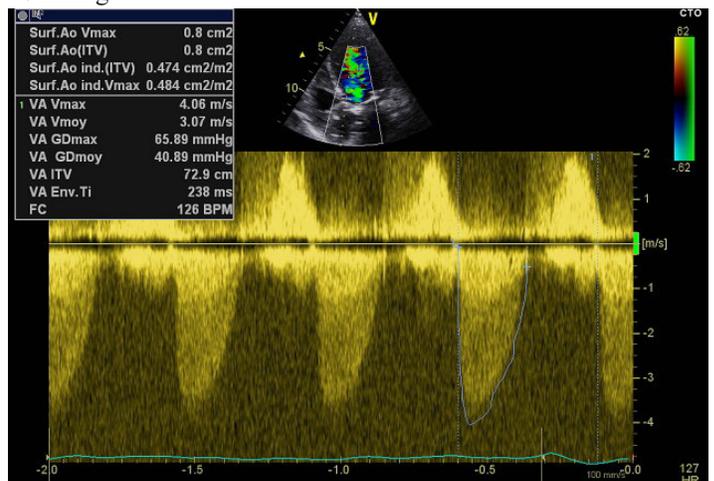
Transthoracic Doppler echocardiography apical five chambers showed calcified severe aortic stenosis with aortic area at $0.4 \text{ cm}^2/\text{m}^2$ (continuity equation), maximum speed: 4.06m/s; Mean gradient: 41 mmhg.
